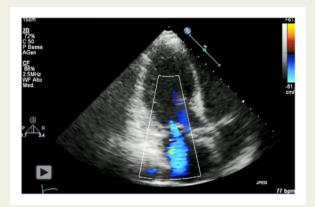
Figure I Transthoracic echocardiography at admission showing signs of congestion such as right pleural effusion (*A*, solid arrow) and left pulmonary comet tails (*B*, dashed arrow), reduced left ventricular function (*C*, left ventricular parasternal short-axis view in diastole and systole), and severe mitral regurgitation (*D*, left ventricular apical long-axis view); following adequate therapy transthoracic echocardiography demonstrated normalized left ventricular systolic function (*E*), and mild residual mitral regurgitation (*F*).
